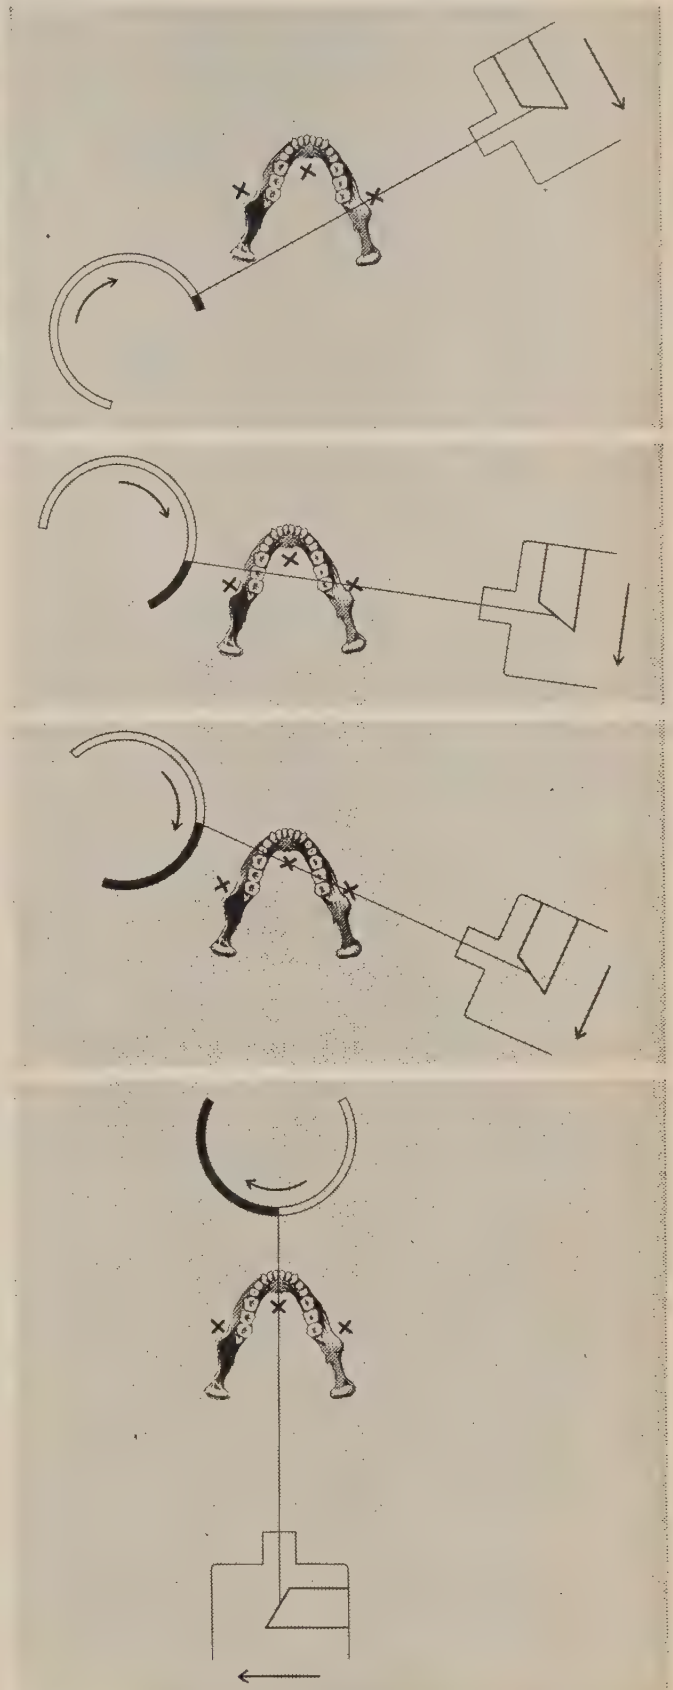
Orthopantomograph principle. X-ray source and film move. Patient is stationary. Rotational axis shifts to three positions. Centres of rotational axis are shown by X. (Updegrave, W.J. D. Radiog. & Photog. 36:75, 1963.)
